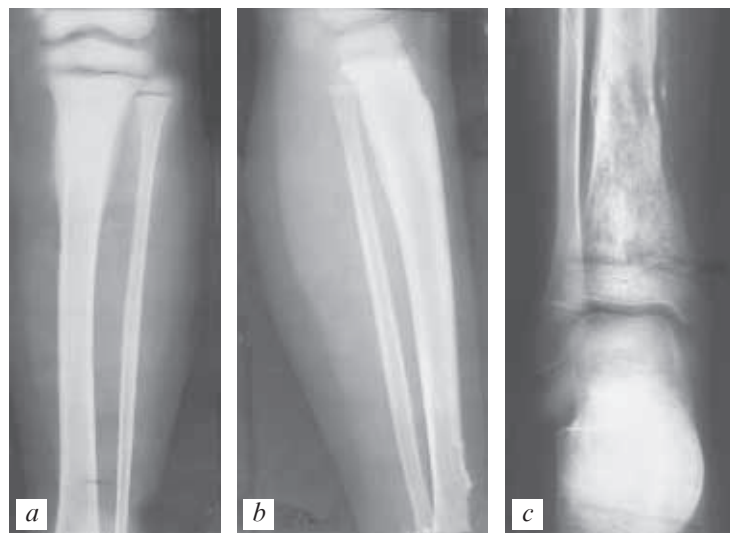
Early radiographic signs of AHO: linear periostitis, osteoporosis (a–c)
